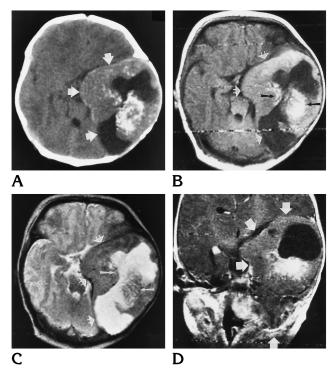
A, Noncontrast CT shows a large partially calcified, partially cystic mass (*arrows*) in the left middle cranial fossa.
